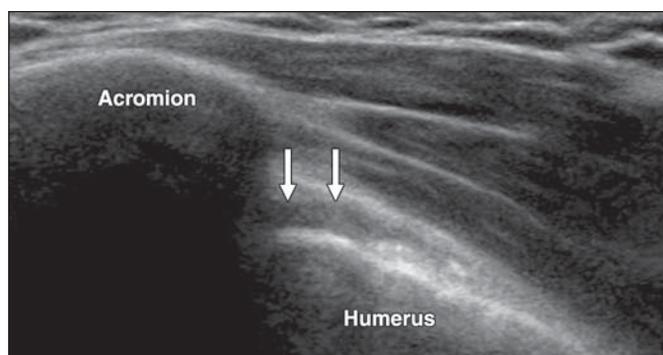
59-year-old man with asymptomatic subacromial impingement. Ultrasound image over lateral acromion in coronal plane with shoulder in active abduction shows pooling of fluid in subacromial-subdeltoid bursa (arrows) between acromion and greater tuberosity.
